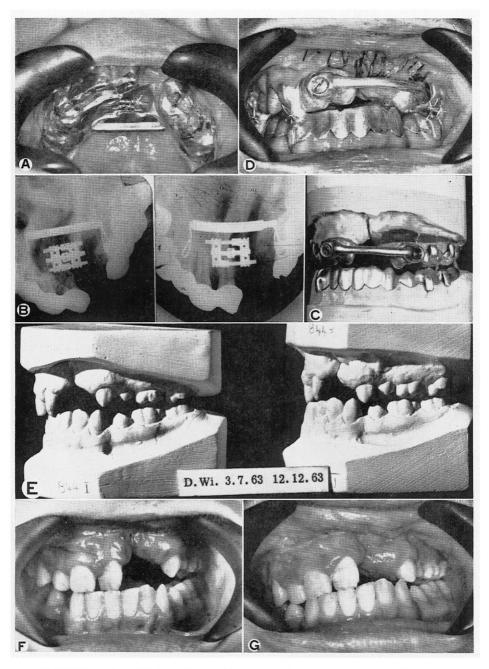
Case IV: lateral open bite. Correction of open bite as well as expansion in unilateral case. (a) Expansion splint in situ. (b) X-ray films before and during expansion. (c) Sectional maxillary splint and locking bar prepared on model together with mandibular splint. (d) Fixation immediately after correction of lateral open bite and insertion of bone graft. (e) Articulated models after expansion, and after correction of lateral open bite and insertion of bone grafts. (f) Bite after expansion but before correction of lateral open bite. (g) Bite after expansion and correction of lateral open bite and insertion of bone grafts.
